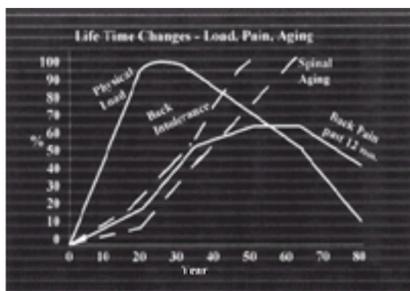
Lifetime changes—load, pain, aging. Note relationships between maximum adult physical load, back pain, and back intolerance relative to spinal aging according to age. (Modified from Videman T, Battié MC, Gibbons LE, et al. Lifetime exercise and disk degeneration: an MRI study of monozygotic twins. *Med Sci Sports Exerc* 1997;29:1350–1356.)
